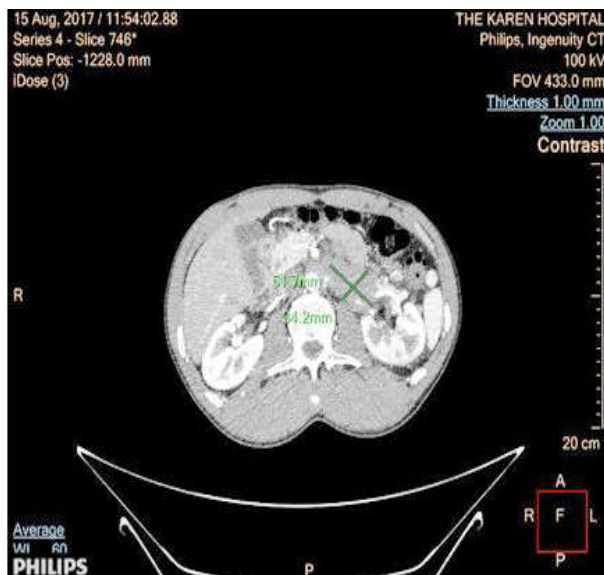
CT Aortogram Axial view
